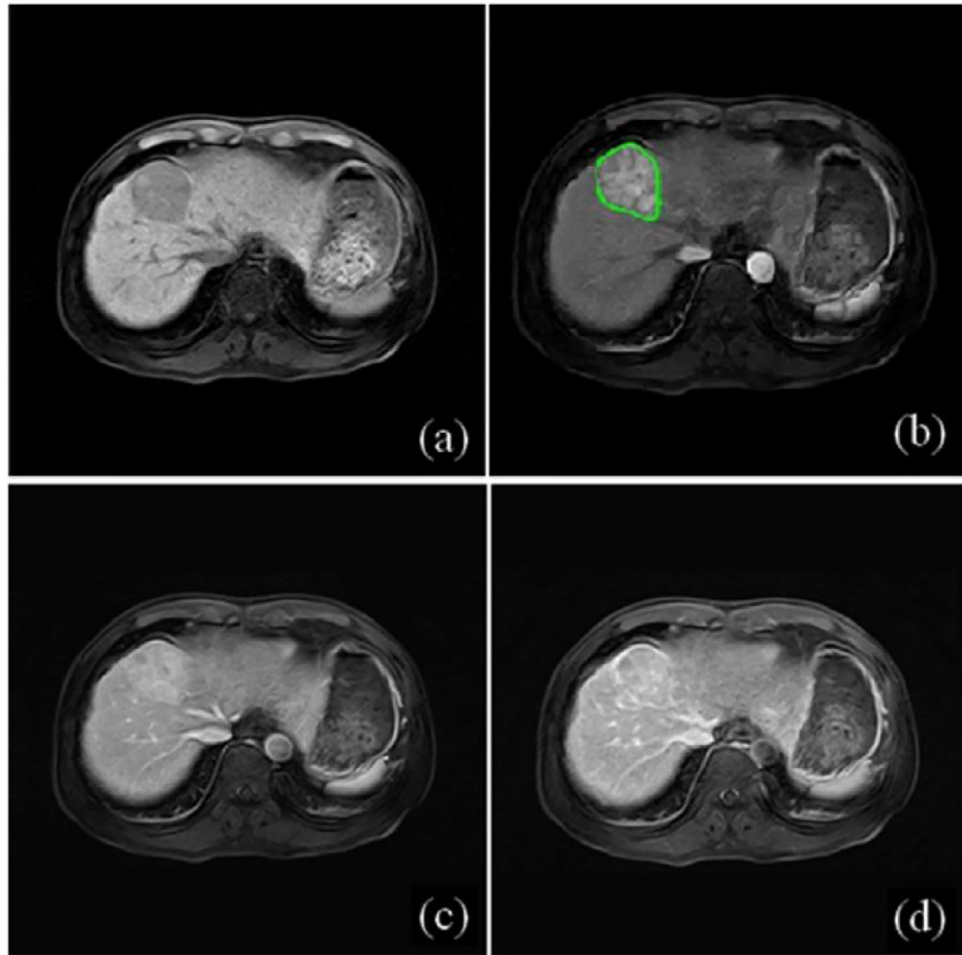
Axial views of contrast-enhanced magnetic resonance images in a 59-year-old man with pathologically confirmed low-grade hepatocellular carcinoma: (a) Pre-contrast phase; (b) Arterial phase; (c) Portal venous phase; (d) Delayed phase. The tumour region is marked in green in (b).
